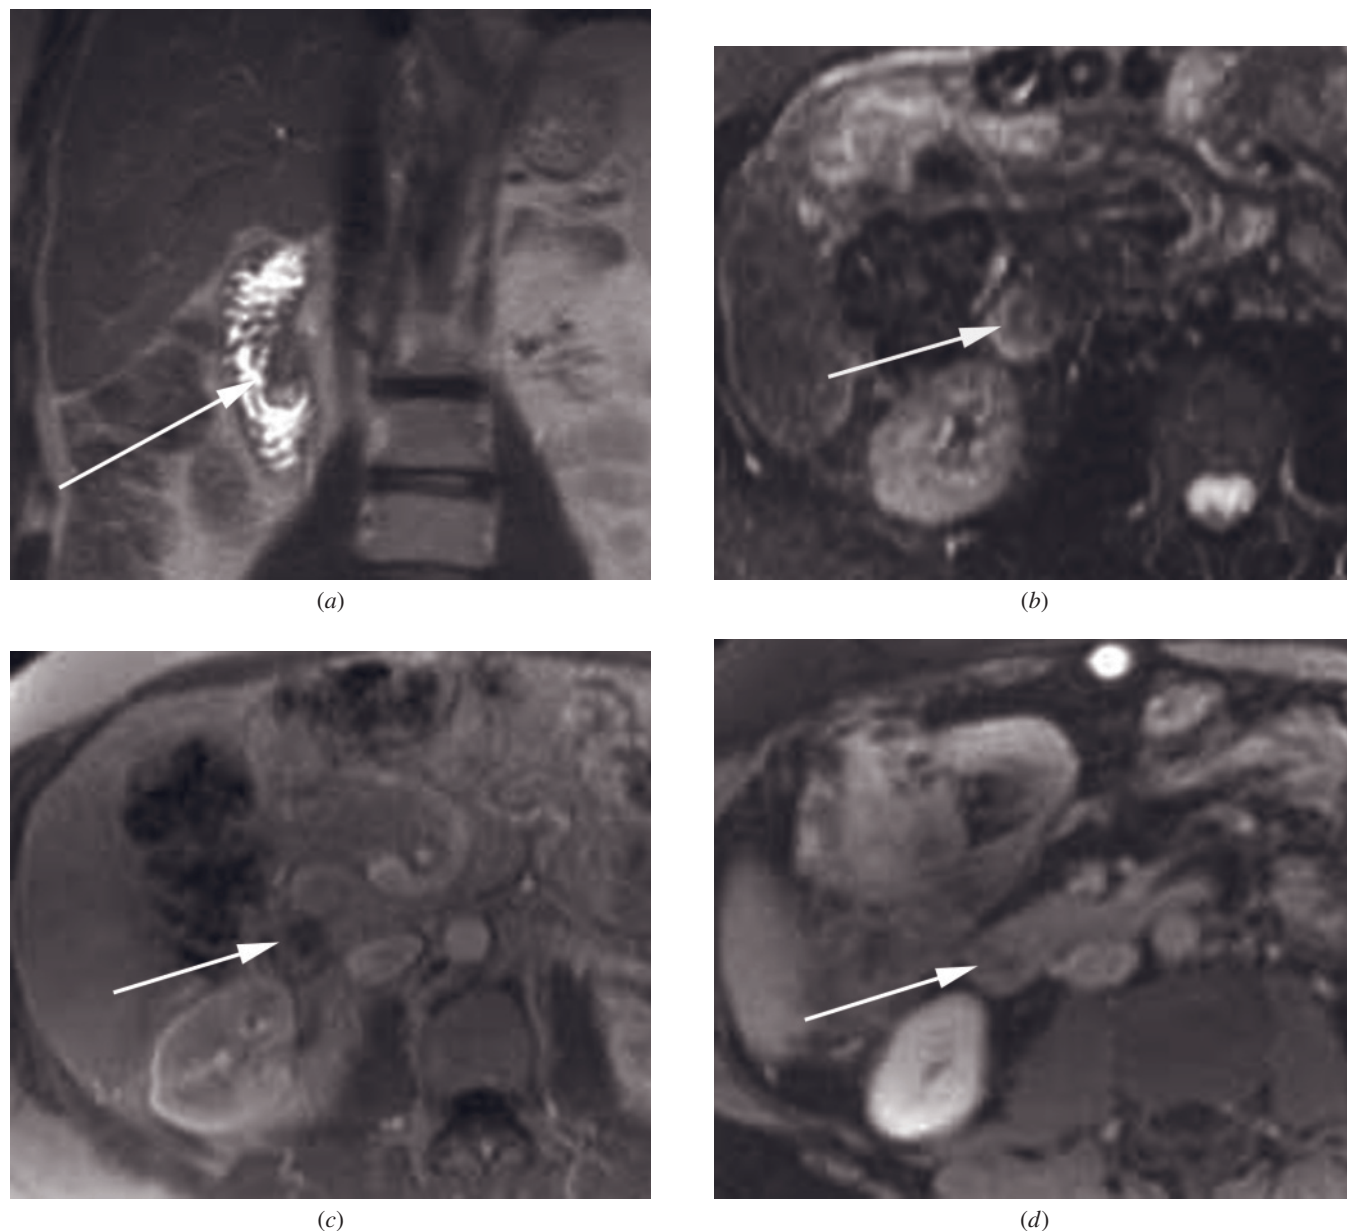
Ampullary adenoma. Coronal T2-weighted echo-train spin-echo (*a*), axial STIR (*b*), axial immediate postgadolinium GE (*c*), and 2-min postgadolinium fat-suppressed GE (*d*) images. A prominent, masslike major papilla (arrows, *a-d*) is observed protruding into the duodenal lumen. Signal intensity and contrast enhancement are equivalent to a normal papilla. No sign of malignancy is observed.
